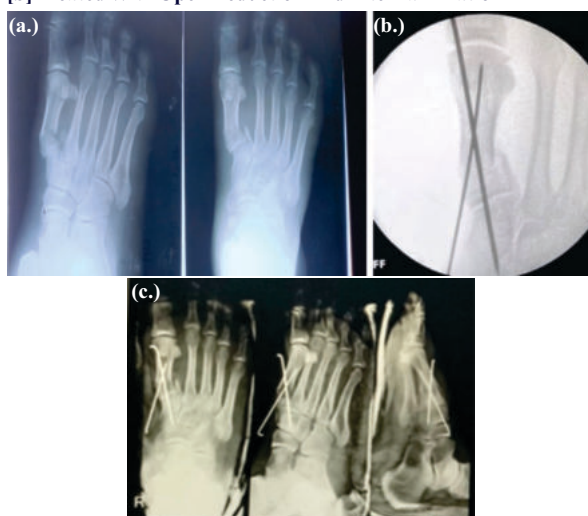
(a.) Pre operative X-ray, (b.) Fluoroscopy image, (c.) Follow up X-ray after 6 weeks
